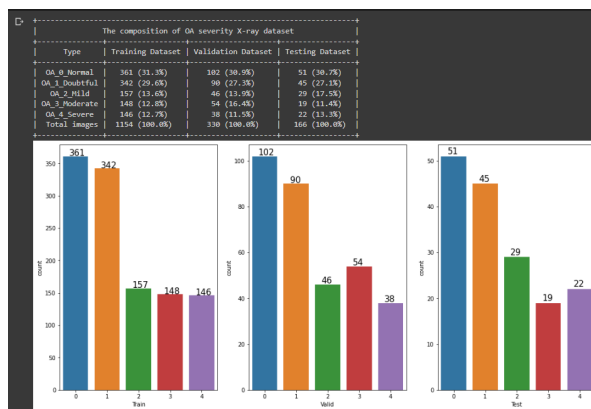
Knee Osteoarthritis Severity X-Ray image data distribution
